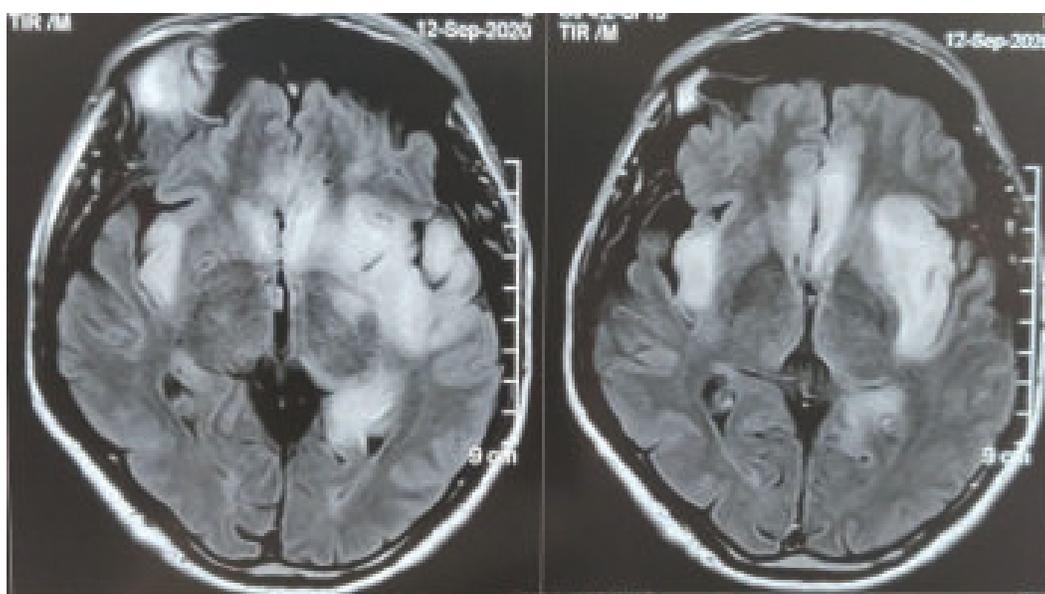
MRI of brain FLAIR sequence showing bilateral hyperintense signal change involving frontotemporal lobes with cerebral edema suggestive of encephalitis
